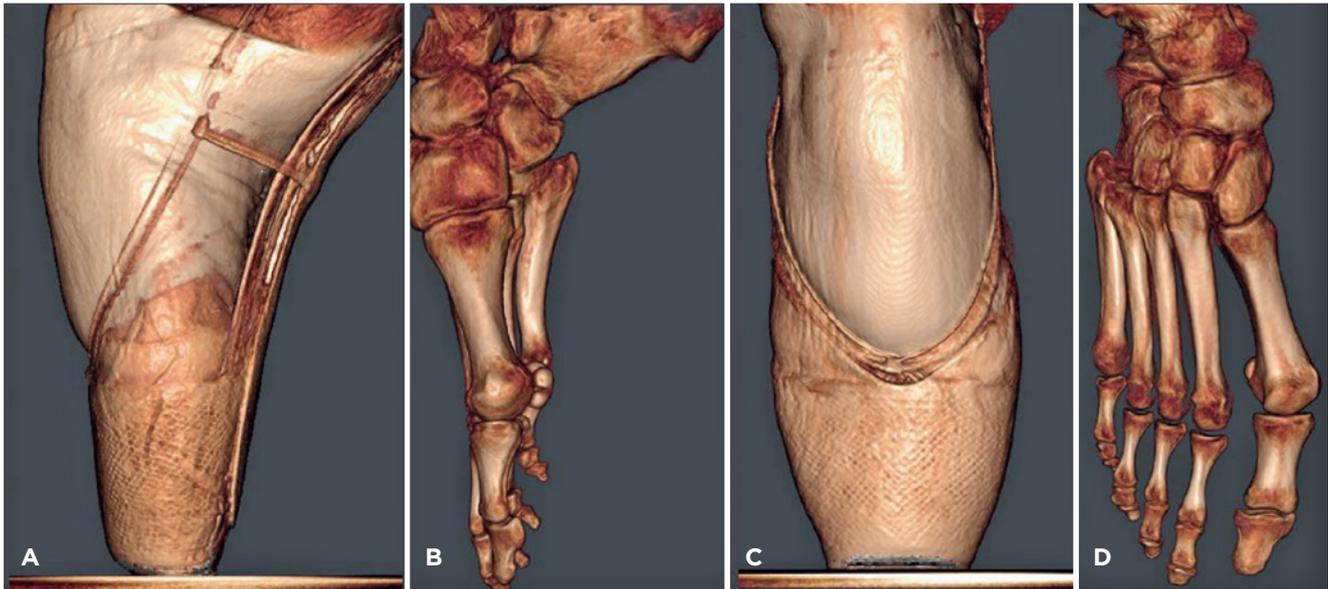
Pointe position weight-bearing computed tomography. A) 3- dimensional image of the foot sagittal view with pointe shoes; B) without pointe shoes; C) coronal view with pointe shoes; D) without pointe shoes.
